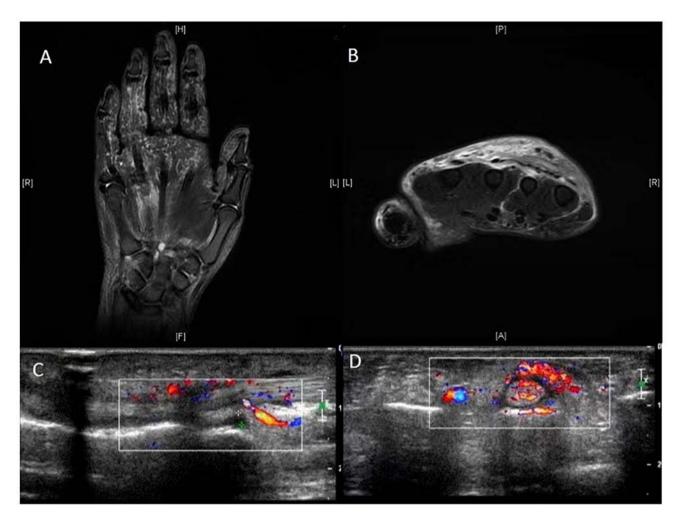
MRI and ultrasound of the hand in patients with PsA and RS3PE. MRI (A) coronal view revealing swelling of subcutaneous soft tissue of the back of the hand and fingers, marked by diffuse strips of fat suppressed T2WI on the ring finger and (B) transverse view revealing diffuse edema at the proximal metacarpal. The subcutaneous soft tissue on the back of the hand was clearly swollen. Ultrasound revealing (C) subcutaneous soft tissue swelling on the back of the hand with an uneven internal echo and (D) annular hypoechoic area around the extensor tendon, indicating subcutaneous soft tissue swelling and an uneven internal echo. MRI, magnetic resonance imaging; R, right; H, head; L, left; P, posterior; F, foot; A, anterior; T2WI, T2-weighted imaging.
